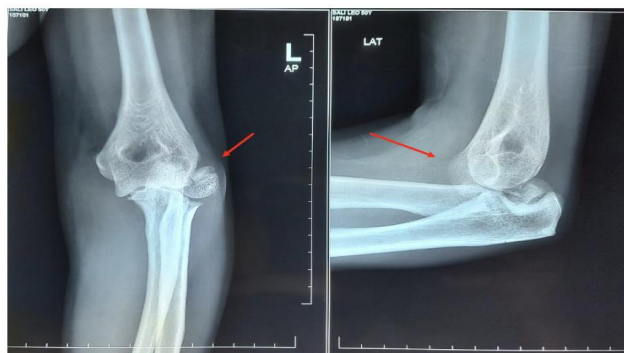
Anteroposterior (AP) and lateral X-ray views of the elbow demonstrated a posterolateral elbow dislocation accompanied by fractures of the radial head and coronoid process, collectively referred to as the "terrible triad" injury
